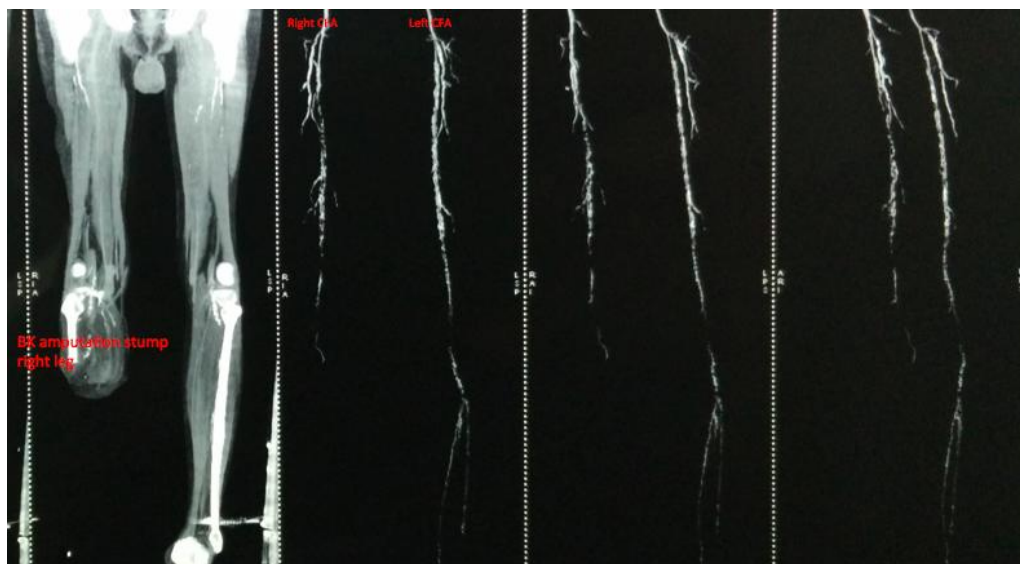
showing CT Angiography which revealed complete occlusion of left common iliac artery (CIA) and partial occlusion proximal right CIA
